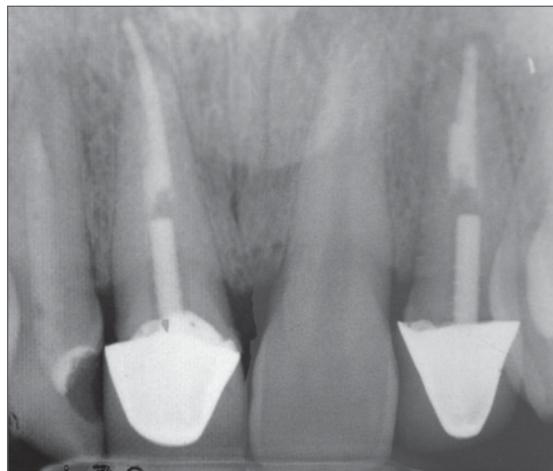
Radiographs showing compromised teeth.
